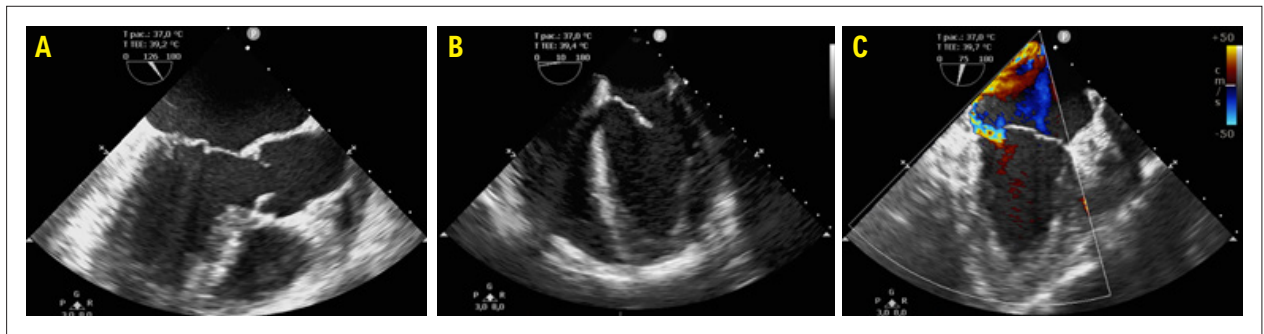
Transesophageal echocardiography demonstrating coaptation displaced toward the posterior leaflet (A), an anterior-to-posterior leaflet ratio > 2:1 (B), and the eccentric jet resulting from ineffective coaptation (C).
